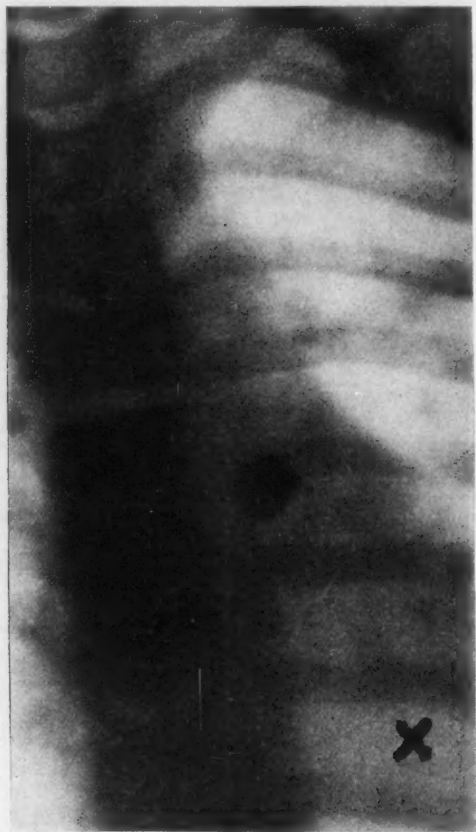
Radiograph shows the location of brad at the time the second picture was made. Location of brad at time of removal is indicated by the X, made between the eighth and ninth ribs.
